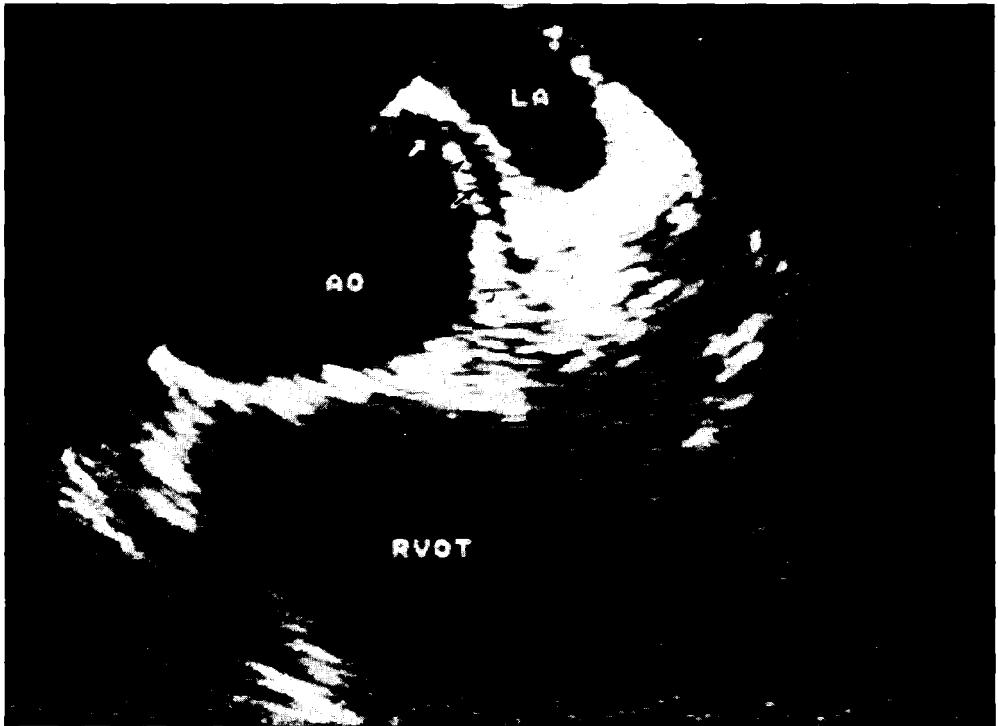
Transesophageal demonstration of a left intramural coronary artery (arrows). Slight variation in transducer insertion documented the origin just above the commissure of the left and non coronary cusp of the aortic valve. Color flow mapping documented laminar flow patterns, excluding any obstruction. Note the acute angulation of the vessel and its intimate relation with the aortic wall.
